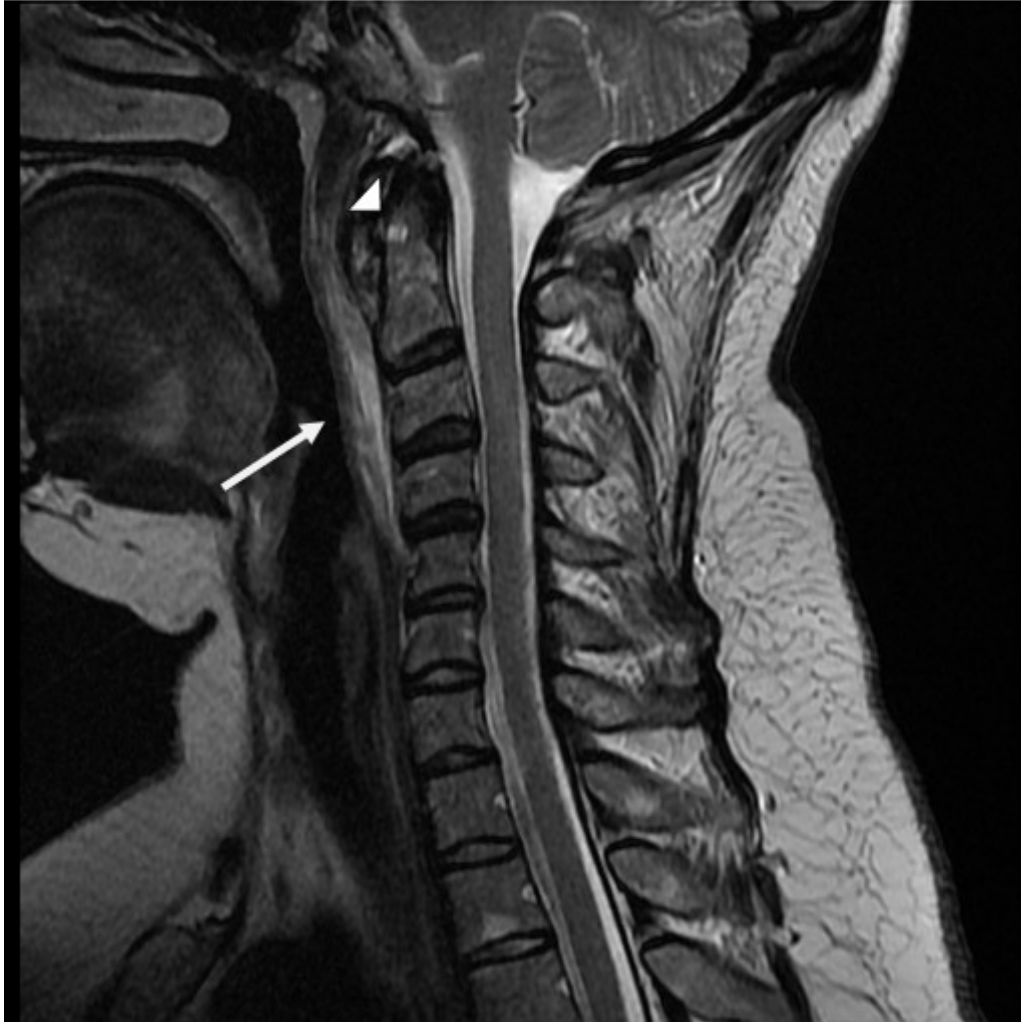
Sagittal T2-weighted FR FSE sequence image demonstrates fluid collection (arrow) within the pre-vertebral soft tissues, with calcification (arrow head) in the proximal fibers of the longus colli tendon.
